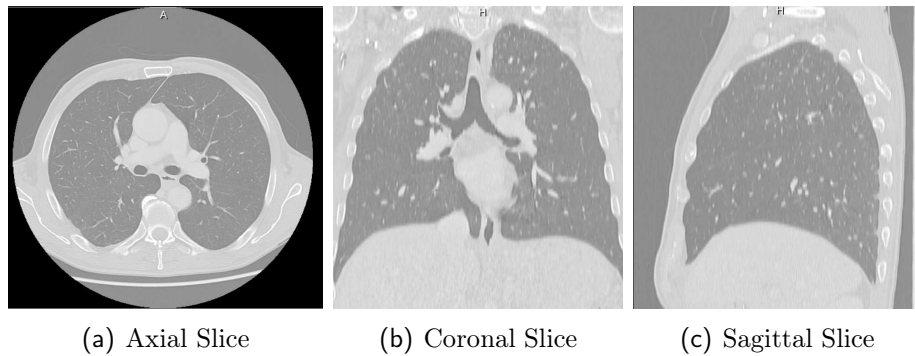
Three orthogonal projections of a CT scan.
